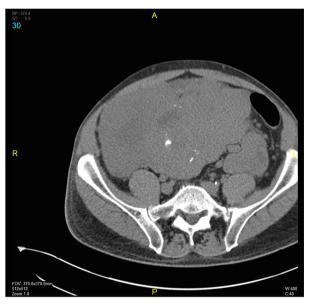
Diagnostic abdominal computed tomography (CT) imaging. A CT scan image shows an abdominal mass measuring 18×24 cm.
